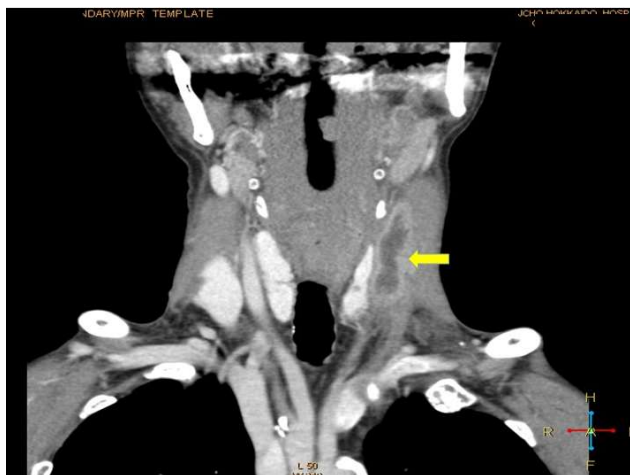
Enhanced cervical computed tomography showing enlargement of left internal jugular vein, in which hypodense lesions compatible with thrombosis can be seen.
